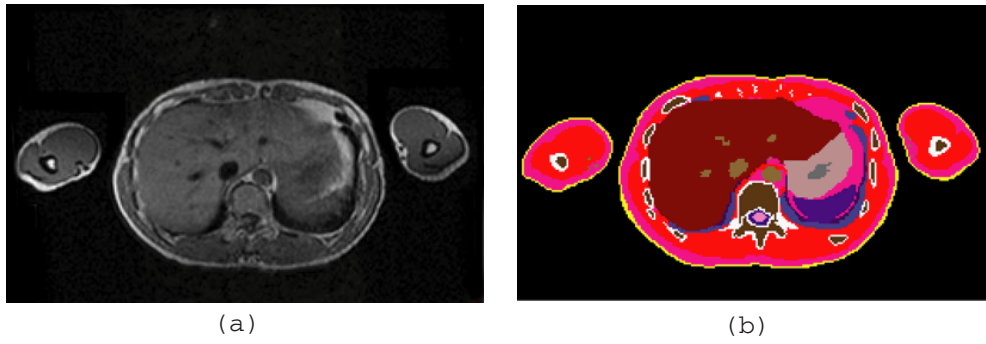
An example of a transverse image before and after identification of tissues and organs. (a) Original MR image at abdomen level, (b) tissue- and organ-identified image at the same level.
